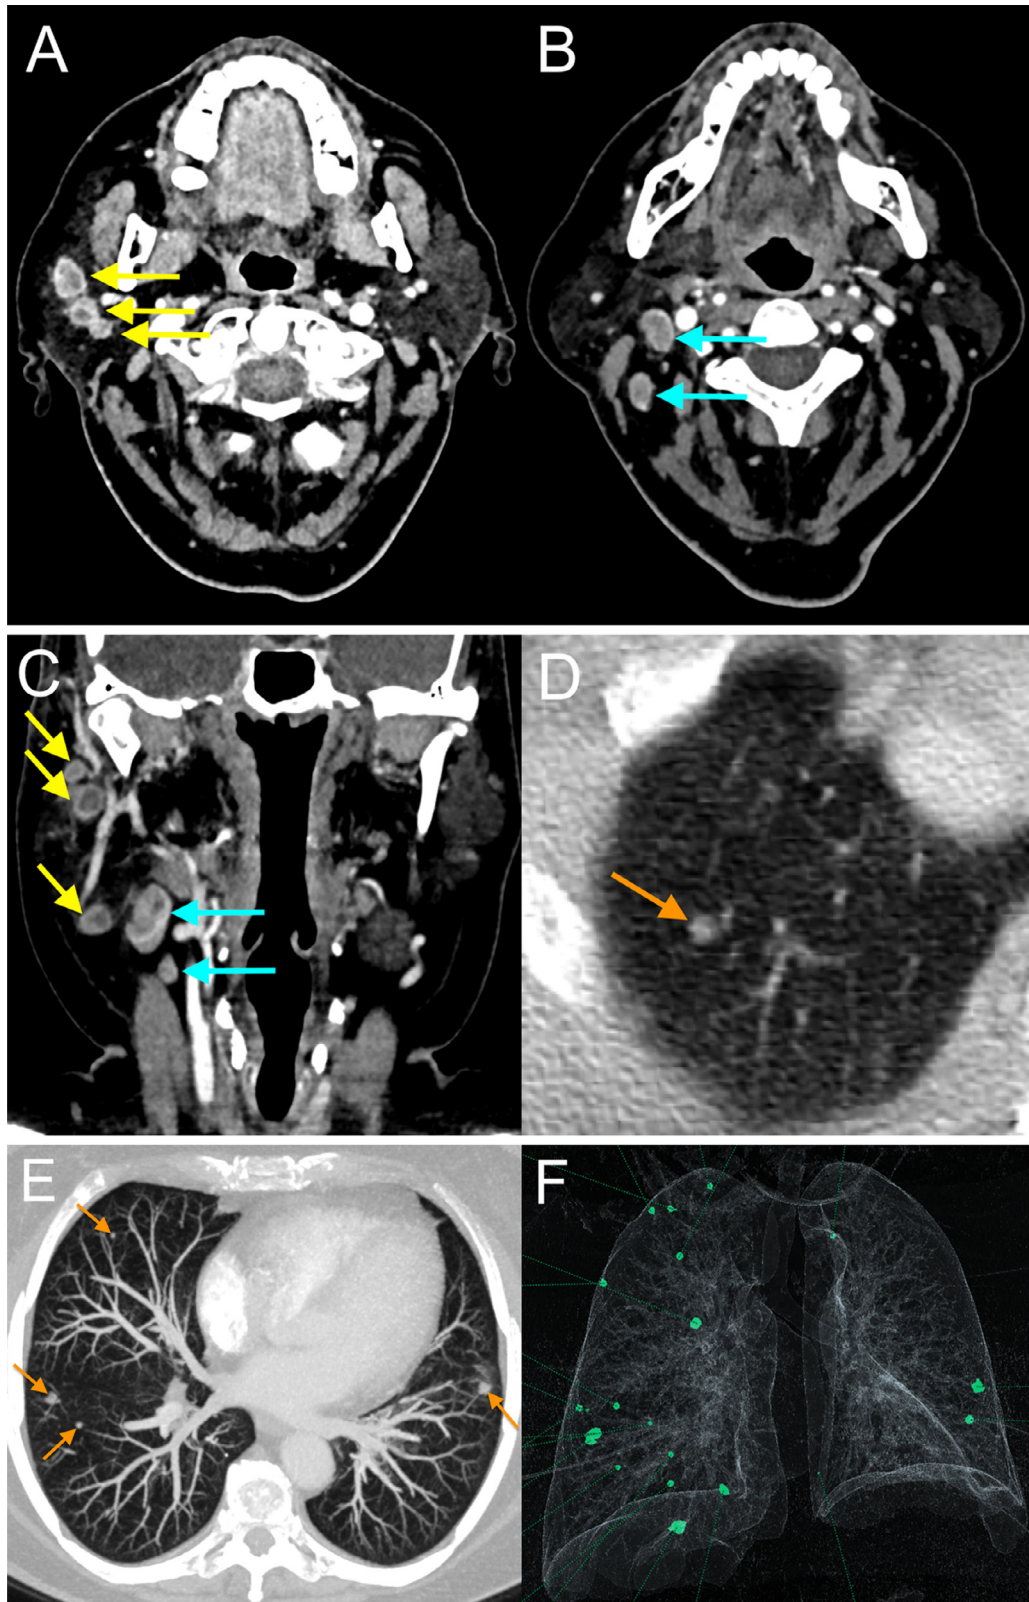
Venous phase contrast-enhanced CT of the neck and chest 5.5 months after presentation. (A-C) CT of the neck demonstrating multiple suspect lymph nodes in the right parotid gland (yellow arrows) and right cervical levels 2-3 (blue arrows). (D) Lung window showing one of multiple millimetric solid lung nodules in the right upper lobe (orange arrow). (E) Chest CT maximum intensity projection (MIP) performed 3 days later showing bilateral solid lung nodules, not demonstrated on preoperative imaging (orange arrows). (F) 3D volume rendering reconstruction showing bilateral metastases (green nodules), predominantly in the right lung.
